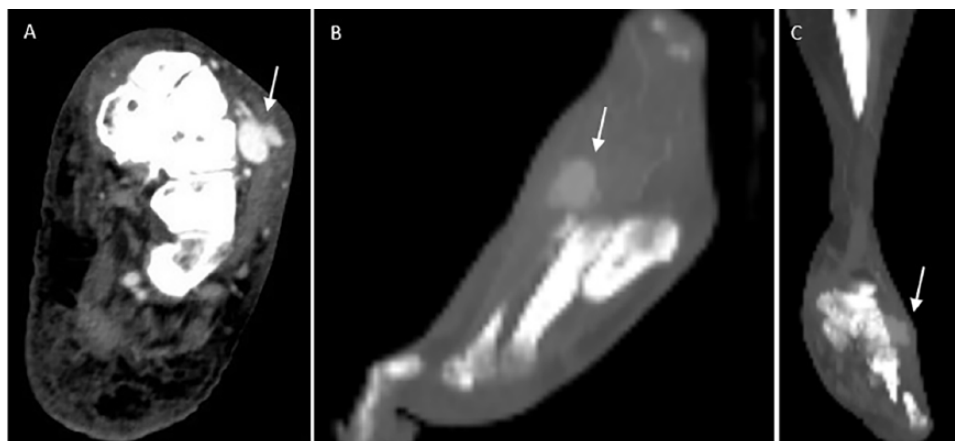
Computed tomography angiogram demonstrating a pseudoaneurysm of the second dorsal metatarsal artery in axial (A), sagittal (B), and coronal (C) planes.
